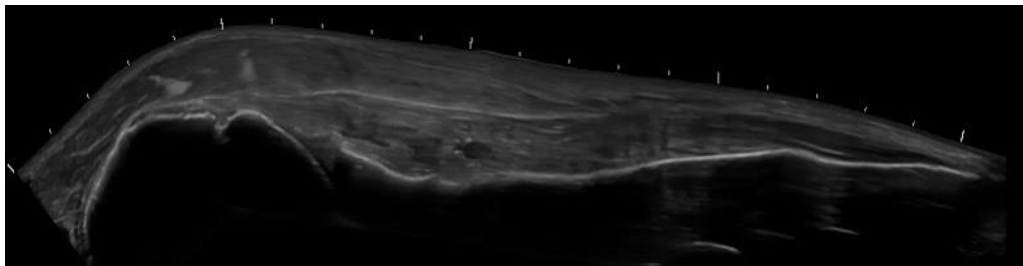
Panoramic ultrasound image of the left shoulder, which was collected from a cadaver.
